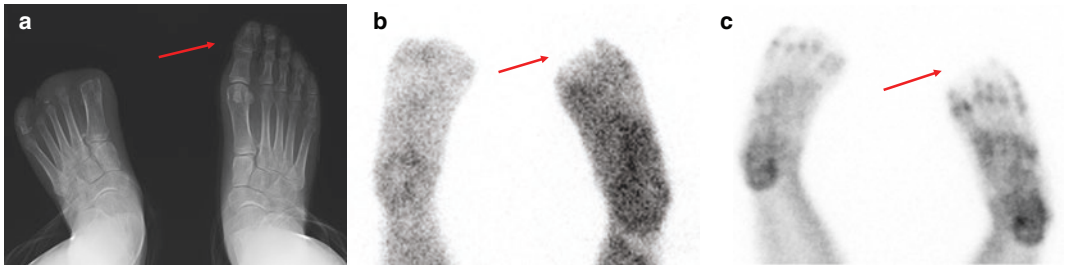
There is no significant abnormal bone lesion in the left foot plain radiography (a). Perfusion defects and loss of bone uptake in the left 1st–3rd toes are clearly
